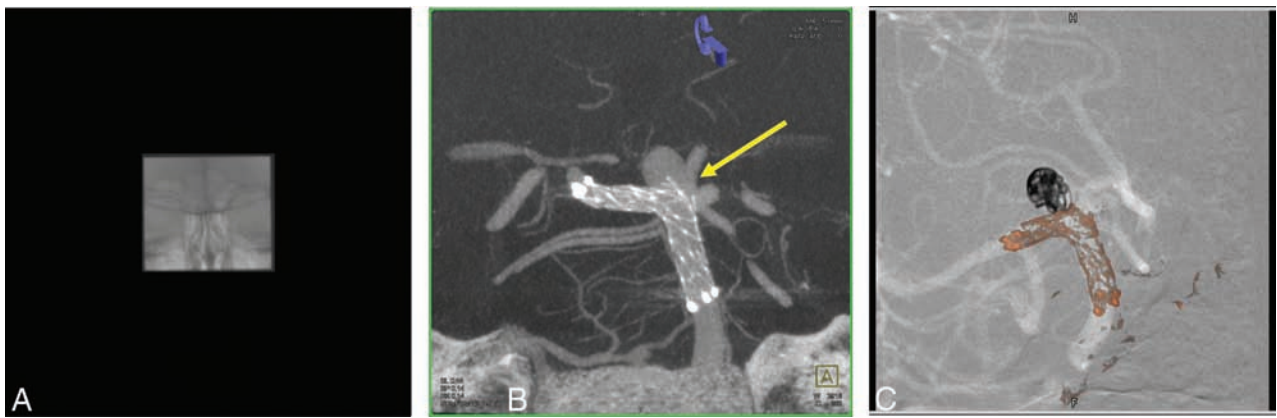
VOI C-arm CT images of a basilar tip aneurysm in a 58-year-old woman treated with stent and coils. Contrast-enhanced VOI C-arm CT images were acquired immediately after the stent was deployed. *A*, Frontal projection of a VOI C-arm CT acquisition. *B*, ATRACT reconstruction of the same VOI C-arm CT. *C*, Fluoroscopic overlay of the stent for assistance during coiling. Note that the high-contrast objects like stents are well-visualized with the VOI C-arm CT images. In this particular example, based on the C-arm CT imaging neck coverage was good after the deployment for first stent from the right side, thus avoiding the need for a second stent.
